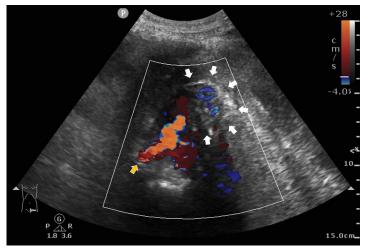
Point-of-care ultrasound in transverse view over left lower quadrant of abdomen demonstrating an extravasating flow from left common iliac artery (yellow arrow) into left psoas muscle (white arrows) under color Doppler display with hypoechoic paraarterial fluid collection.
